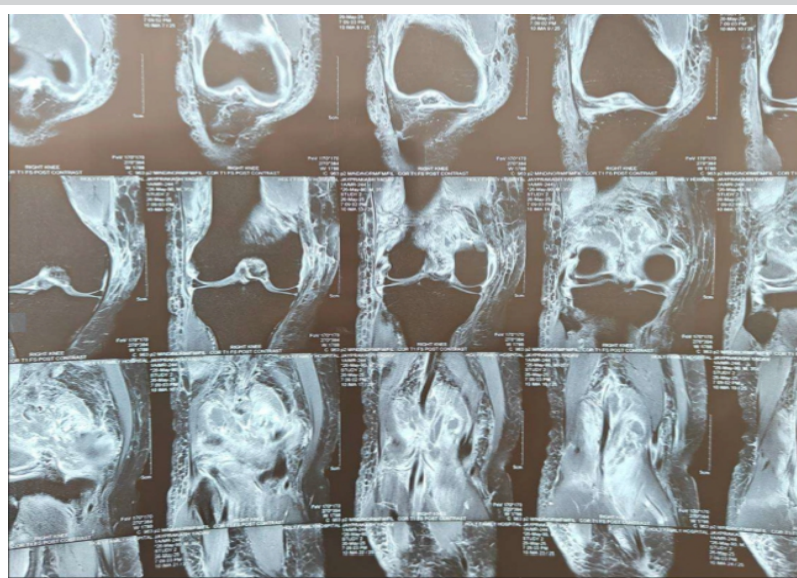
Coronal magnetic resonance imaging image of the knee showing intramuscular collections.
